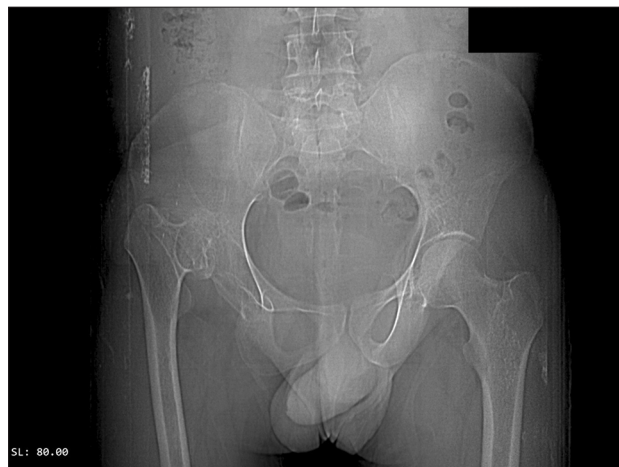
Preoperative radiograph showing dislocation of the right femoral head with proximal migration in patient 1.
